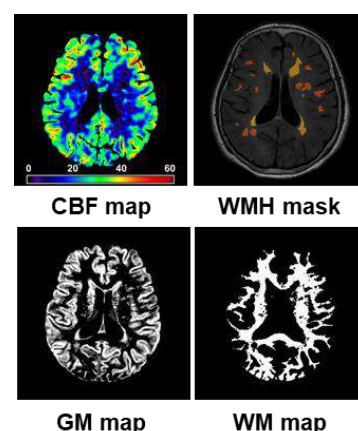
Typical MR images.
